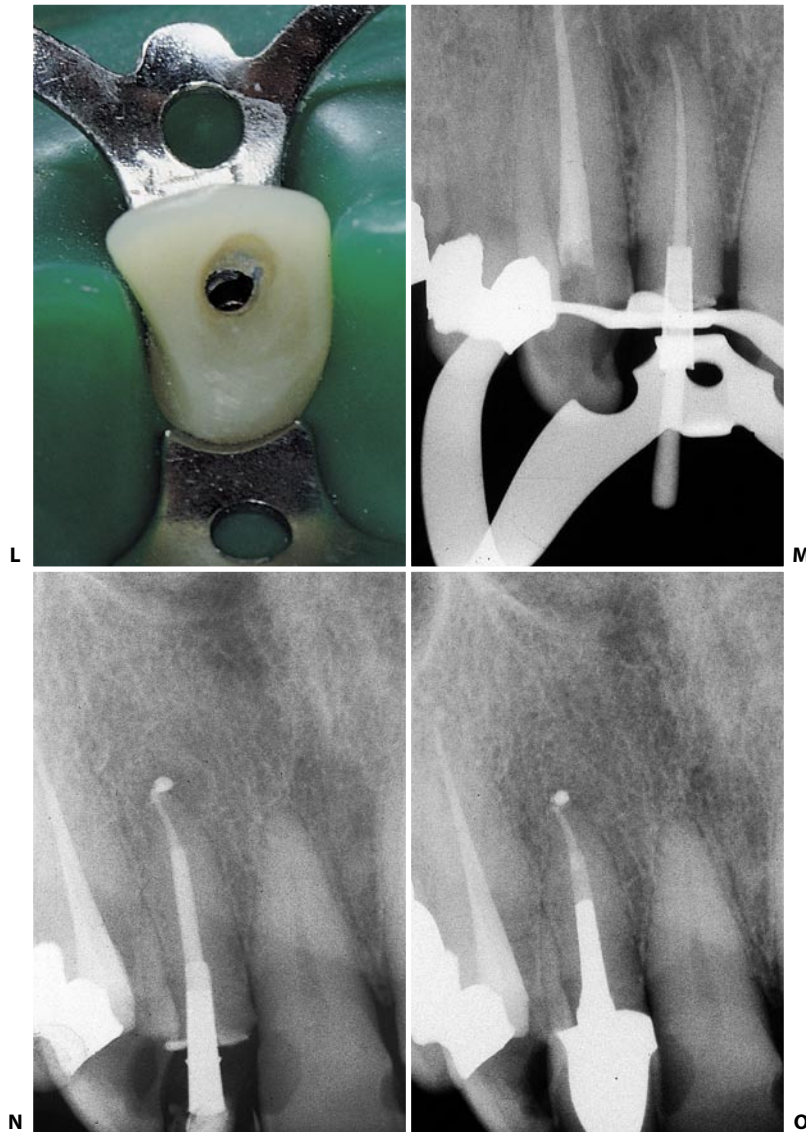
(continued) L. The access cavity prepared as far as finding of the hollow post within the temporary, after having removed the gutta-percha cone. M. Intraoperative radiograph of the cone fit. N. Postoperative radiograph. O. Recall radiograph one year later.
